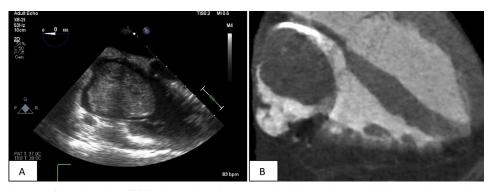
(A) Midesophageal four-chamber TEE view with a focus on the right atrium and right ventricle: a large mass is occupying most of the right atrium with partial herniation across the tricuspid valve during diastole. (B) Computed tomography heart morphology study showing the right atrial tumor herniating across the tricuspid annulus in diastole.
